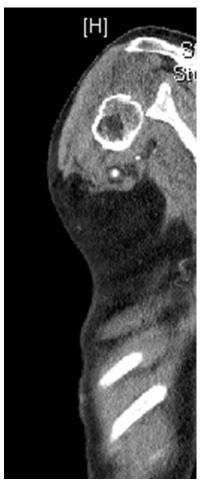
Computed tomography imaging demonstrates an inferior dislocation of the glenohumeral joint.
